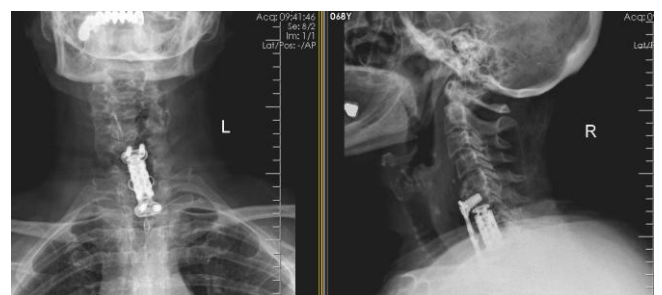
Anterior and lateral cervical X-rays show the anterior plate and retractable titanium cage following the second operation.
